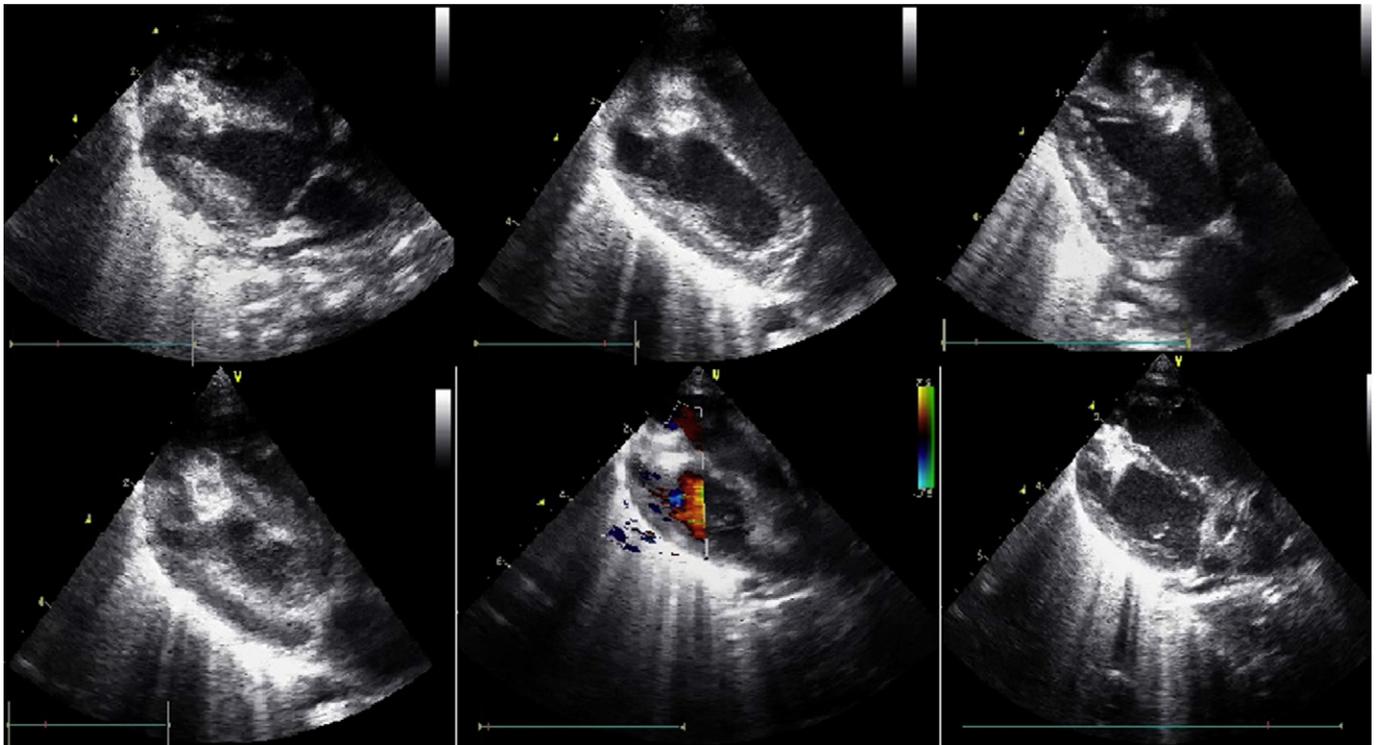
Transthoracic echocardiography images after VSD closure.
